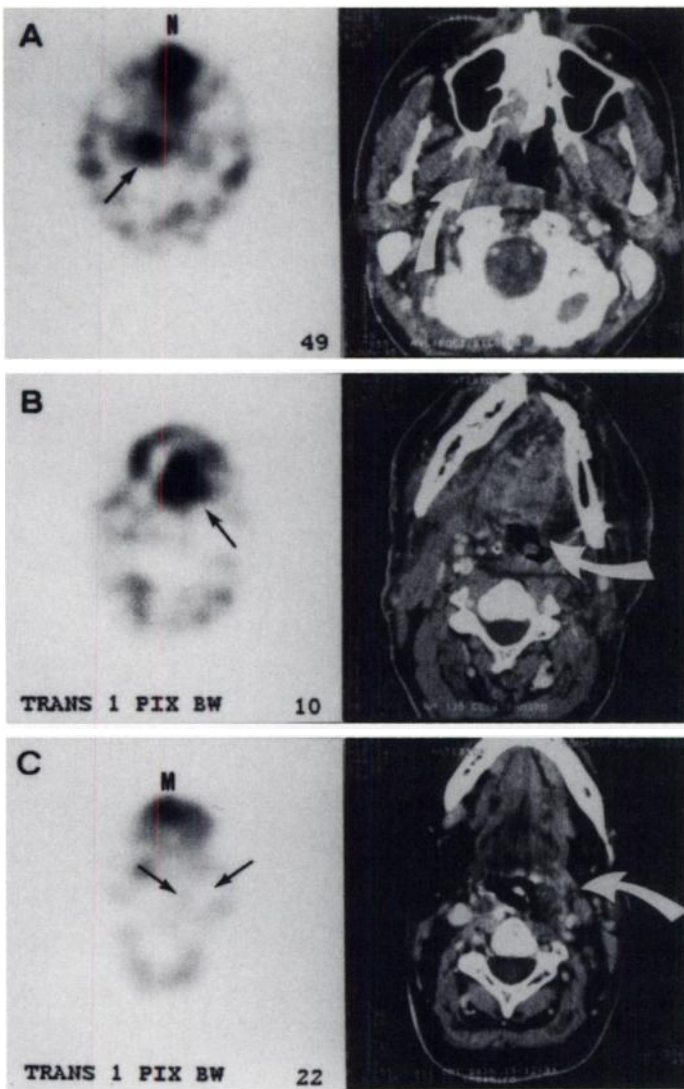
Transaxial images of ^{201}Tl SPECT (left) and enhanced CT (right) of three patients suspected for tumor recurrences in (A) nasopharynx, (B) floor of mouth and (C) supraglottis. SPECT, confirming recurrences in nasopharynx and floor of mouth, shows viable tumor (black arrows on A and B) more accurately than CT (white arrows) especially for recurrence of floor of mouth in which CT was not conclusive. By contrast, SPECT is negative in left supraglottis area (black arrows on C), whereas CT is not conclusive in excluding recurrence (white arrow). Activity in mouth (M) and nose (N) are also observed on SPECT.
